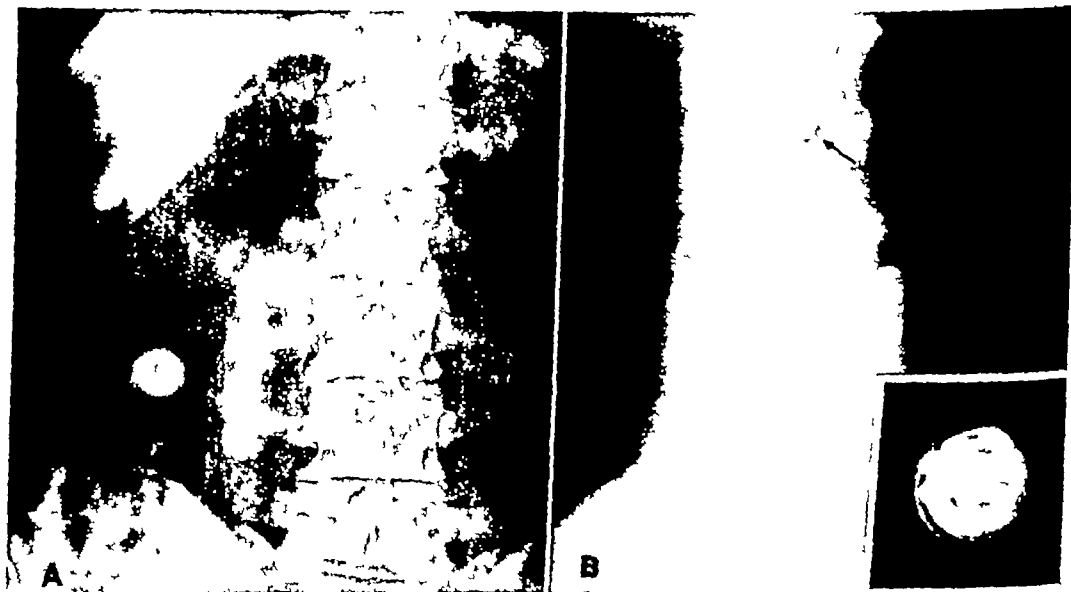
Case 8 A Anteroposterior view of abdomen showing laminated calculus above right iliac crest. B Lateral view showing calculus (arrow) lying far posteriorly in abdomen. Inset: Roentgenogram of calculus showing laminations.
